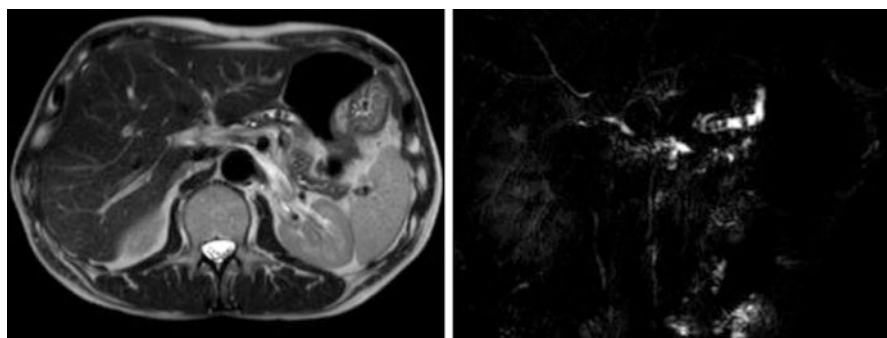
Pancreaticojejunal stricture. MRI scan showing dilated pancreatic duct which contains multiple calculi with a stricture at pancreatojejunal anastomosis (right). MRCP of same patient demonstrating dilated duct and stones (left). This patient had a Whipples procedure for focal pancreatitis in the head of pancreas and developed this complication 4 years later. He also is having recurrent pancreatitis in his pancreatic remnant and is currently being assessed for potential completion pancreatectomy and islet auto transplantation
